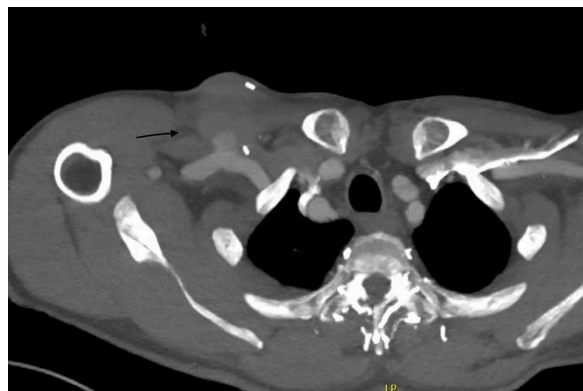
The patient underwent a CT scan that demonstrates a pseudo aneurysm of the right subclavian artery.
